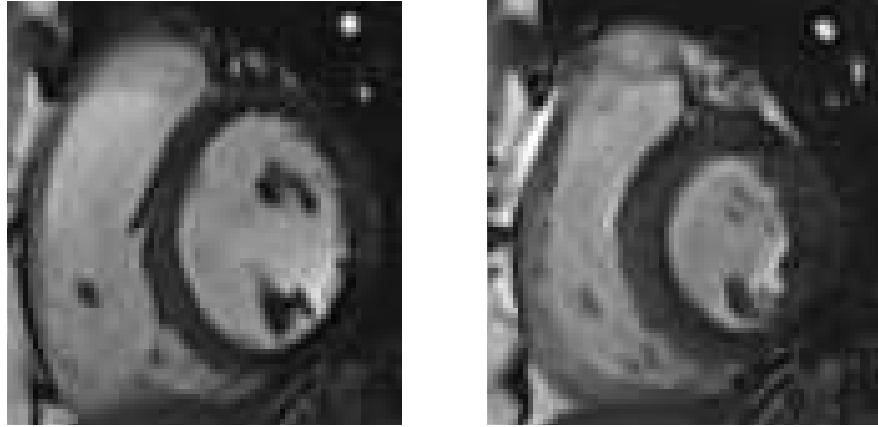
Representative MRI slices at diastole and systole
